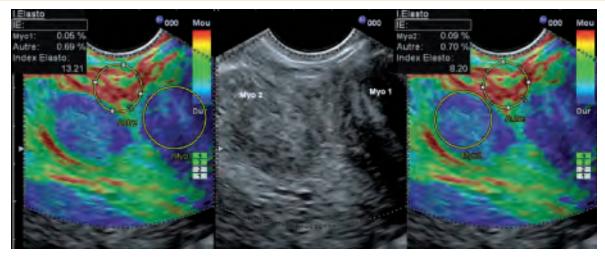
A real-time elastosonographic images of the two fibroids. The strain ratio is evaluated by comparing the mean strain in a region of interest centered on the fibroid, with the mean strain in a region of interest in the surrounding myometrium close to the probe¹⁰
